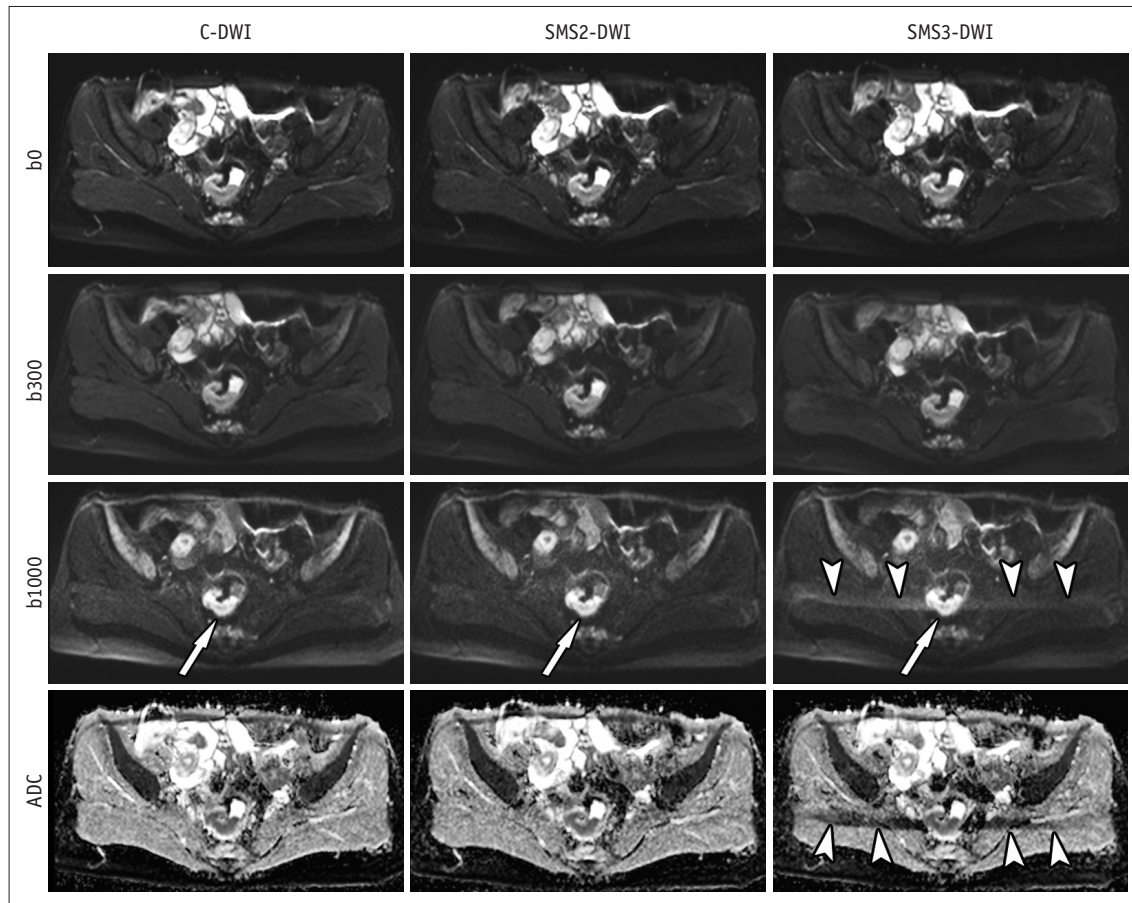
C-DWI and SMS2-DWI and SMS3-DWI in 41-year-old female with rectal cancer. Image set consists of b0, b300, b1000, and ADC map. Image quality and lesion conspicuity for rectal cancer (arrows) in SMS2-DWI (overall image quality score: 4 by both readers) are not significantly different from those in C-DWI (score: 4 by both readers). However, SMS3-DWI (score: 3 in both readers) shows significant aliasing artifacts (arrowheads) and worse image quality in comparison with C-DWI and SMS2-DWI. b0, b = 0 s/mm²; b300, b = 300 s/mm²; b1000, b = 1000 s/mm². ADC = apparent diffusion coefficient, C-DWI = conventional DWI, DWI = diffusion-weighted imaging, SMS = simultaneous multislice, SMS2-DWI = SMS accelerated DWI with acceleration factor of 2, SMS3-DWI = SMS accelerated DWI with acceleration factor of 3
